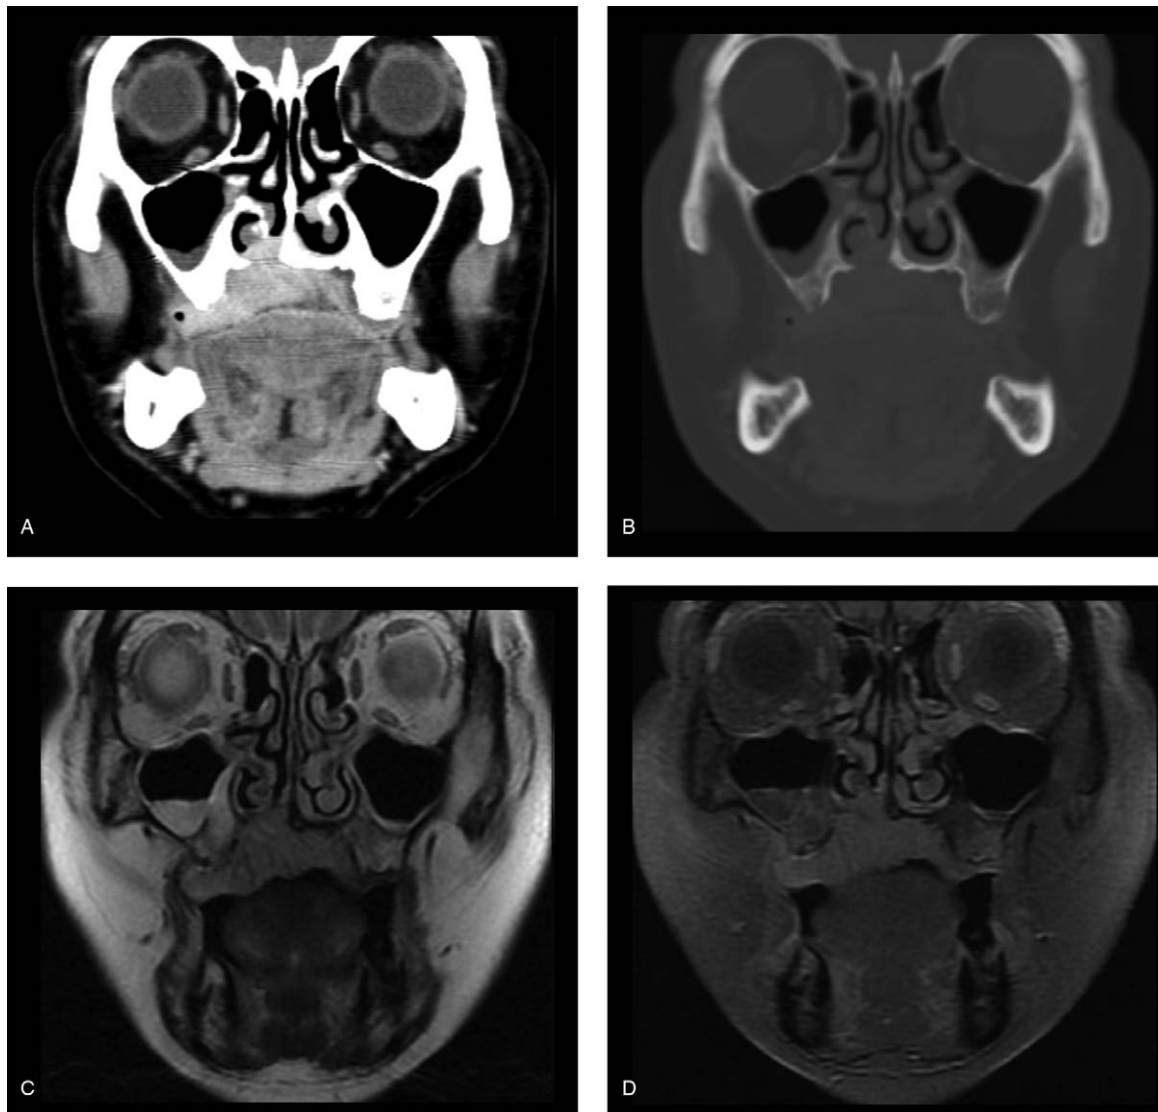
Radiologic images showing an enhancing mass on the palate, destructing the palatine process of the maxilla and infiltrating into the nasal cavity. Coronal images of contrast-enhanced CT with soft tissue window (a), with bone window (b), T2-weighted MR (c), and postcontrast MR (d).
